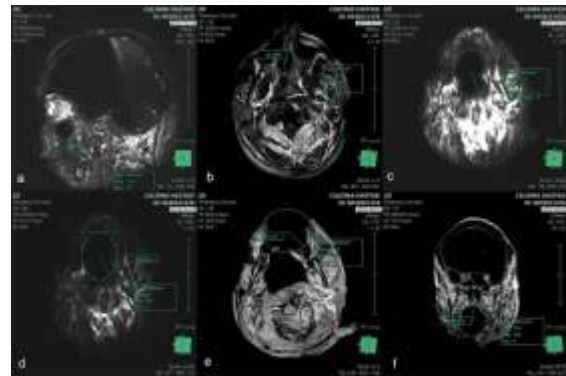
Artifact measurements of ceramic brackets. a, 3D flair sagittal plane; b, T₂ axial plane; c, DWI axial plane; d, DWI sense axial plane; e, T₁ axial plane; f, T₁ coronal plane
